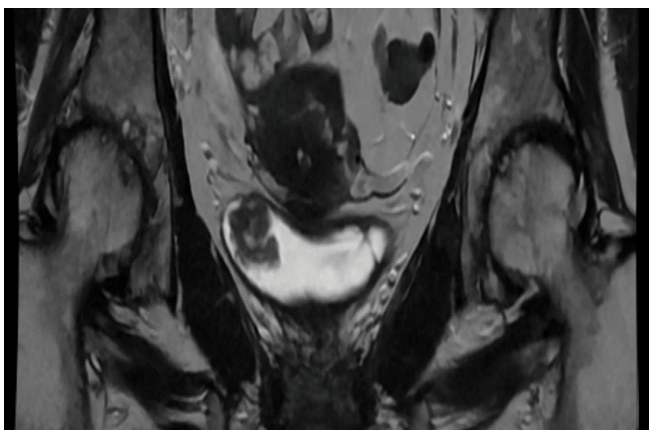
MRI image showing lesion along right side of bladder.
